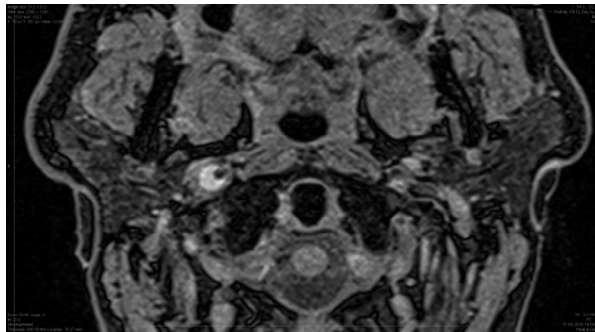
Intramural haematoma of right internal carotid artery on MRI in T1-dependent spin echo (SE) sequence with fat signal saturation (FATSAT)
